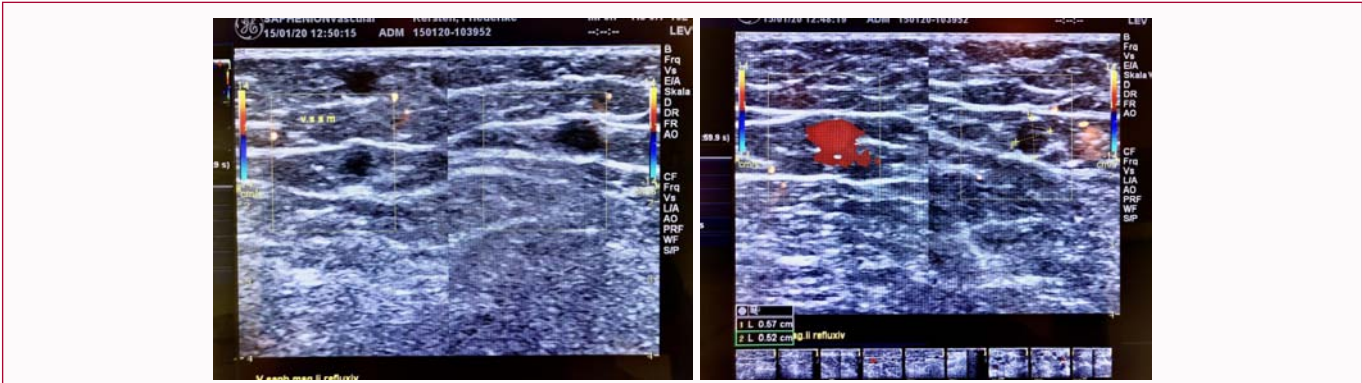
Duplex sonography pare op GSV and VSAM left leg.
